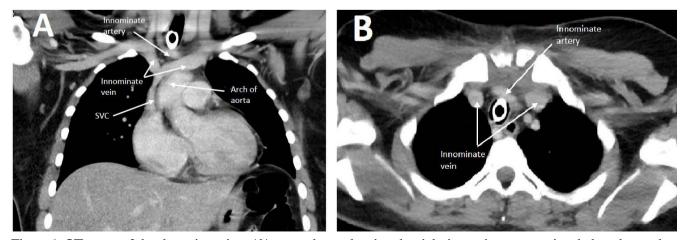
CT scans of the thoracic region: (A) coronal cut, showing the right innominate artery just below the tracheostomy tube and it is normally located; (B) axial cut, showing the evidence of sternotomy, innominate artery located anterior of the tube and posterior to the sternum. SVC – superior vena cava.
